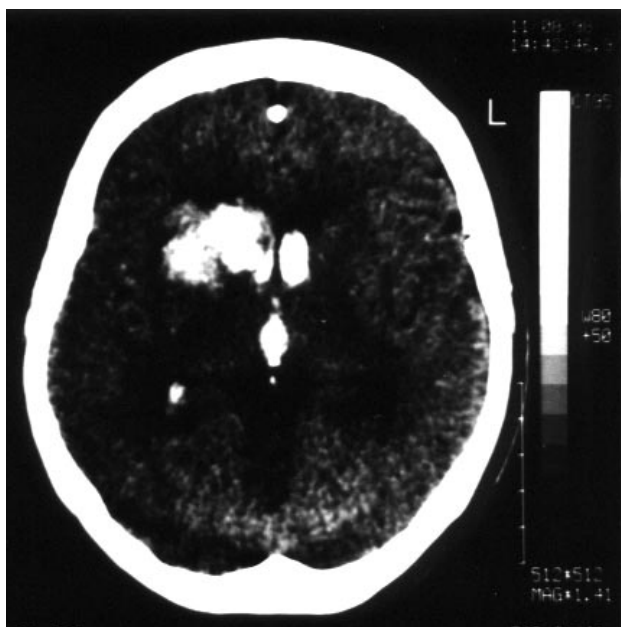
Figure Caudate hemorrhage associated with open ventricular bleeding in axial section of CT.
